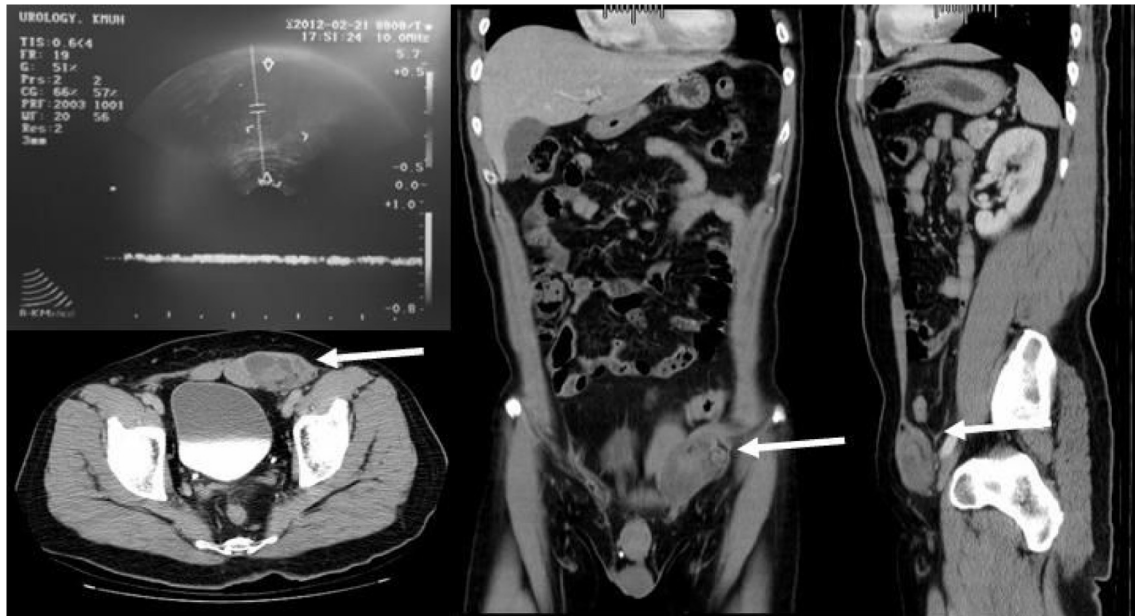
Doppler ultrasonography reveals a mass approximately 4.35 cm in diameter in the left inguinal canal and no flow in the center of the mass with a rim of peripheral flow. Computed tomography reveals a left cryptorchidism with hemorrhage and infarction, and findings are consistent with a torsion of undescended testis, with suspected superimposed inflammatory process or malignant change.
